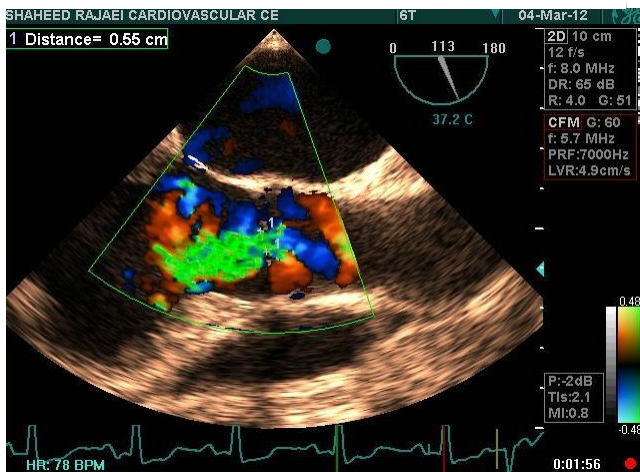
Transesophageal echocardiography shows severe AI.
